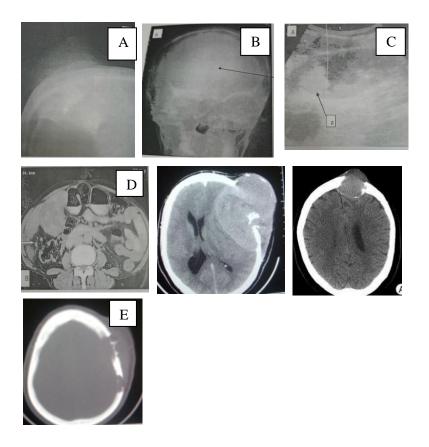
X-ray images of the skull show a soft tissue swelling on the head(A) and bone destruction (B), Ultrasonography image of abdomen(C) showing enlarged gallbladder with fungating tissue; computed tomography images of abdomen(D) showing enlarged gallbladder filled with cancer cells and gallstones extending to surrounding liver tissue and (E) computed tomography of the head showing brain cancer with skull erosion and extension to the scalp.
